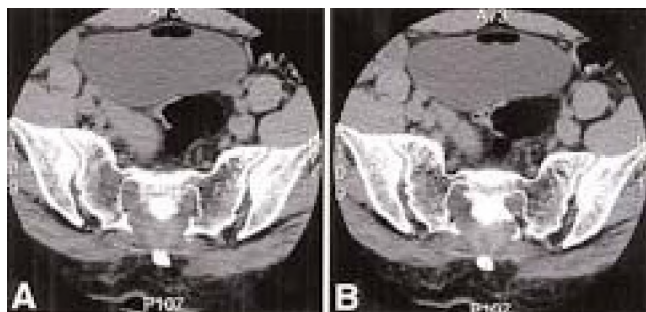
A and B: Postoperative CT myelograms demonstrating obliteration of the cyst cavity with a muscle graft occupying the space formerly filled by the cyst.
